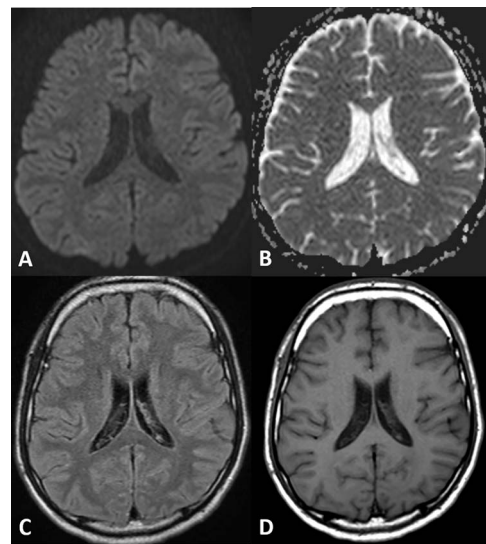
Follow-up brain MRI conducted on the 11th day. (A) Axial diffusion-weighted image, (B) ADC, (C) fluid-attenuated inversion recovery image and (D) T1WI. Follow-up MRI showed no lesions on any sequences.
